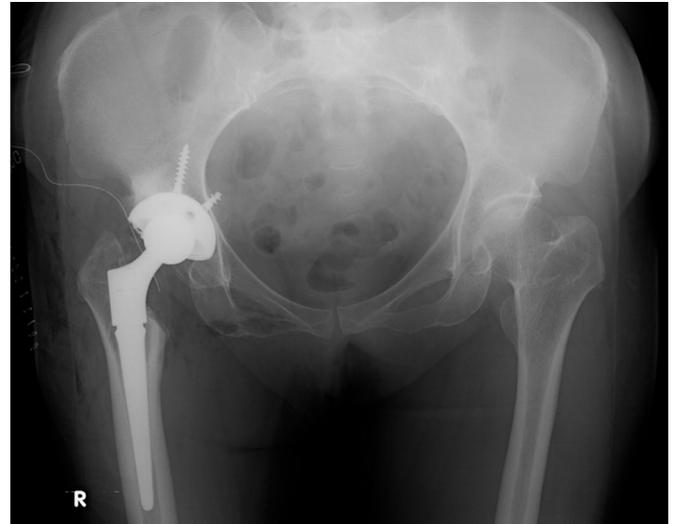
Postoperative radiograph. This postoperative radiograph of a 51-y-old female study patient shows a prosthetic hip center located at a higher point than the anatomical hip center and lower than the tip of great trochanter.
